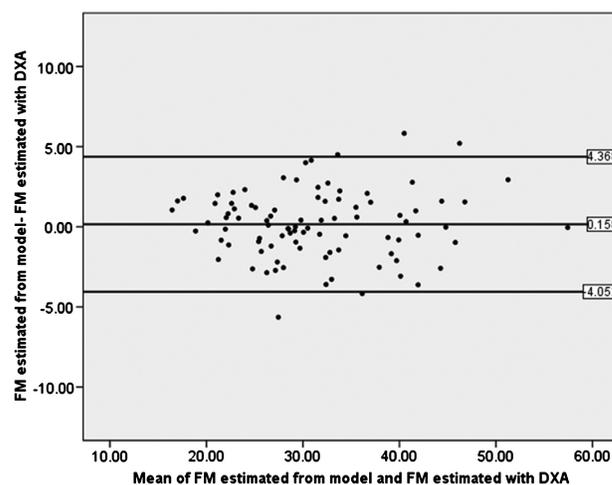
Bland-Altman plot for the developed model. FM, fat mass; DXA, dual-energy x-ray absorptiometry.
